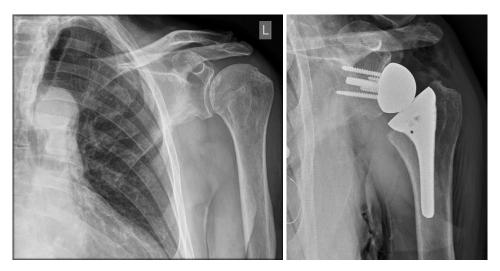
preoperative x-ray of osteoarthritic shoulder (left) and postoperative x-ray after a reverse total shoulder arthroplasty procedure (right)
